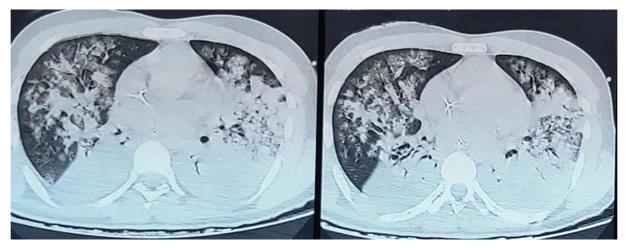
Chest-CT scan revealing diffuse bilateral lung contusion and ground glass opacities.
